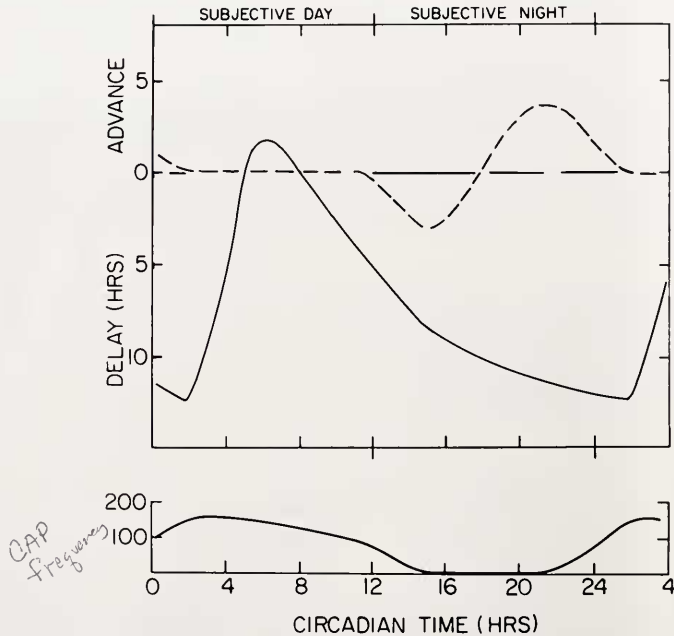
Phase response curves (PRC) for anisomycin (solid lines) and light (dotted lines) for the *Aplysia* eye rhythm. The time scale is circadian time divided into subjective day (00–12) and subjective night (12–24). The transition from phase delays to phase advances occurs about CT 18 for light pulses but at about CT 5 for anisomycin. The bottom of the figure shows the CAP frequency rhythm for phase reference. Adapted from Jacklet, 1977 and 1978.
